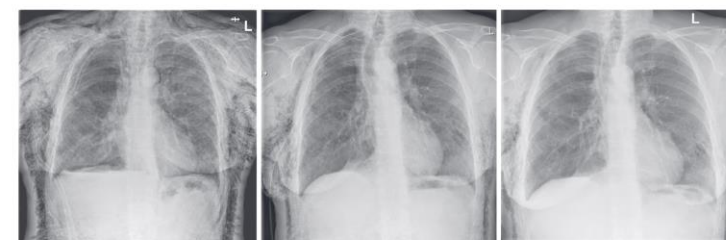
Anteroposterior plain radiographs showing the course of subcutaneous emphysema before and after NPWT. (A) Chest radiograph prior to initiation of NPWT showing massive subcutaneous emphysema and a right-sided pneumothorax of 5 cm. (B) Chest radiograph 48 hours after start of NPWT demonstrating substantial improvement of subcutaneous emphysema and pneumothorax. (C) Chest radiograph 5 days after start of NPWT, presenting only a small amount of residual subcutaneous emphysema. NPWT, negative pressure wound therapy; L, patient's left side.
